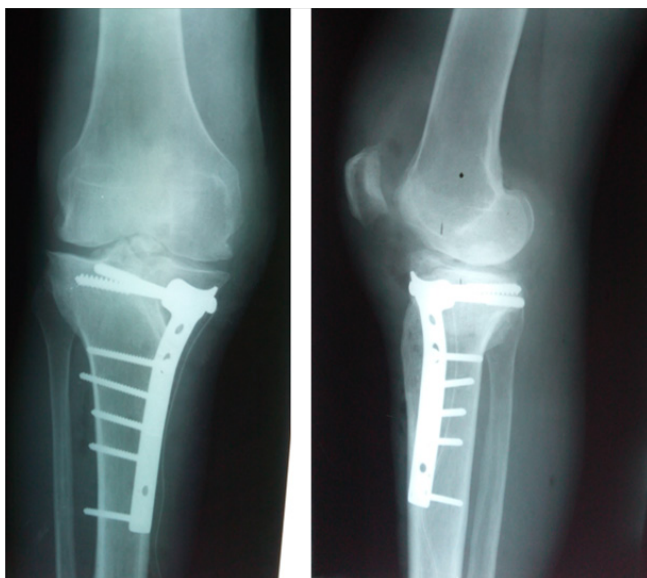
postoperative frontal and sagittal radiography
